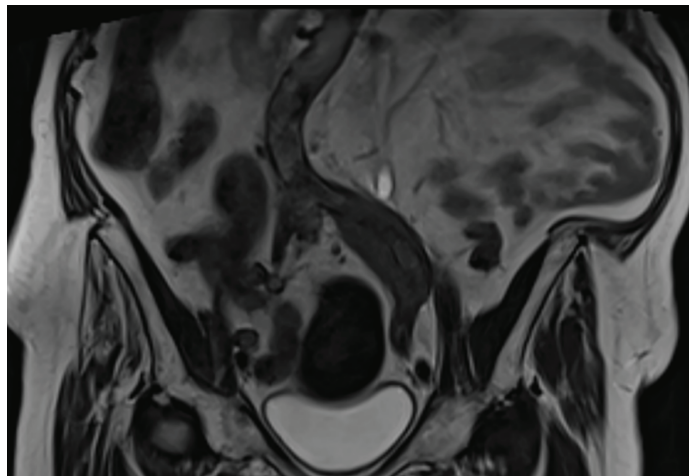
MRI indicated retroperitoneal fibrosis.
